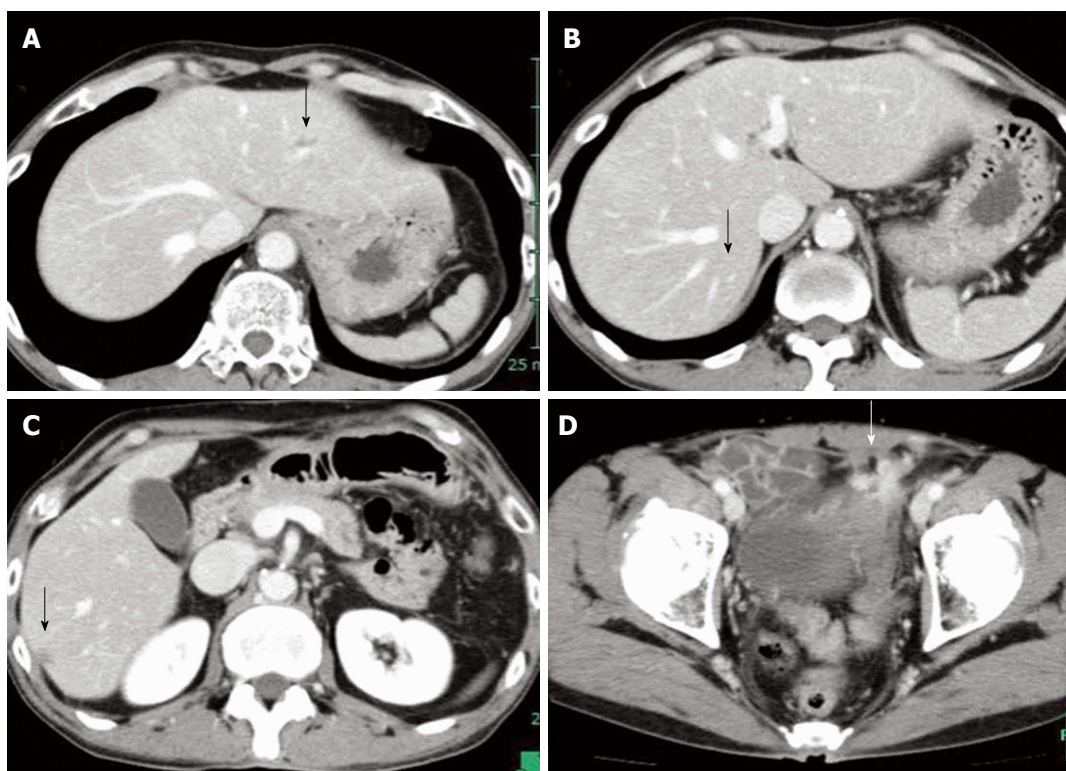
The computed tomography findings after 6 cycles of mFOLFOX6 plus cetuximab chemotherapy showed a good response in both the liver metastases (arrows) and primary lesion. A, B: Liver metastases; C, D: Primary lesion.
